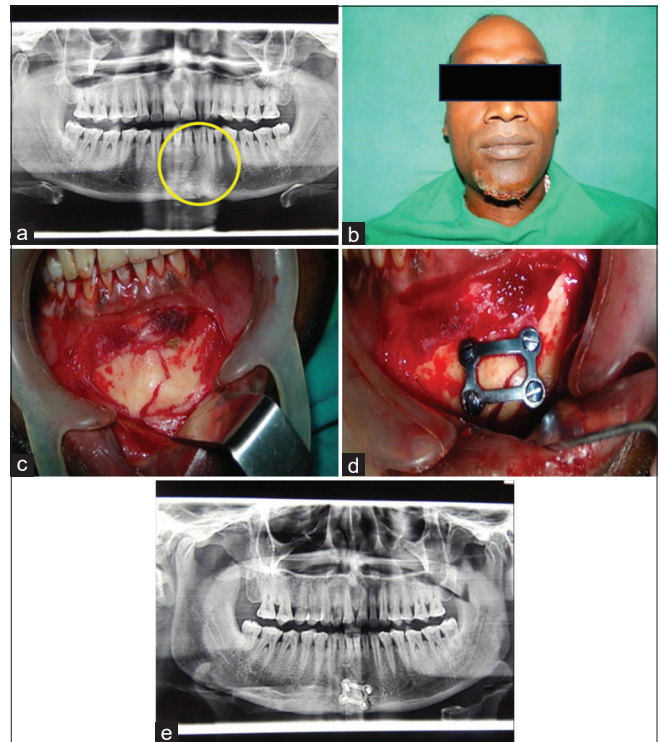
(a) Pre-operative profile of symphysis fracture with laceration on chin. (b) Pre-operative radiograph shows mandibular symphysis fracture. (c) Fracture site exposed. (d) Fracture fixation done with 3D titanium plate. (e) Post-operative radiograph
